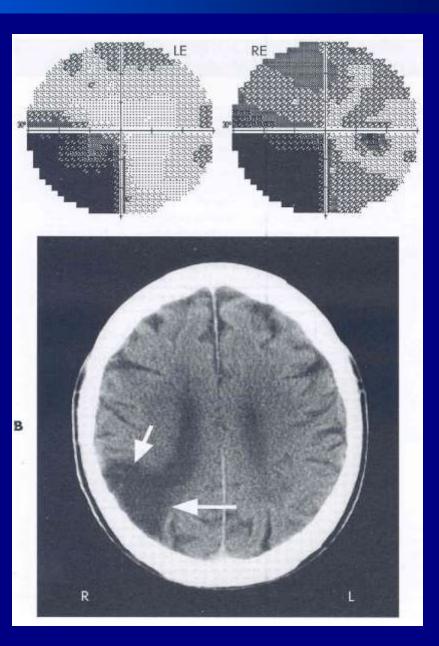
9—A 41-year-old woman presented visual problems and headache. Her acuity was 20/20 OD and 20/30 OS. A, B, Her visual fields demonstrate an incomplete inferior left homonymous hemianopia and suggest an enlarged blind spot on the right side as well as superior arcuate defects. MRI shows a lesion in the parietal lobe that is low intensity on T1-weighted images (C) and high intensity on proton density images (D). These findings are compatible with a glioblastoma. The arcuate defects were due to papilledema.
